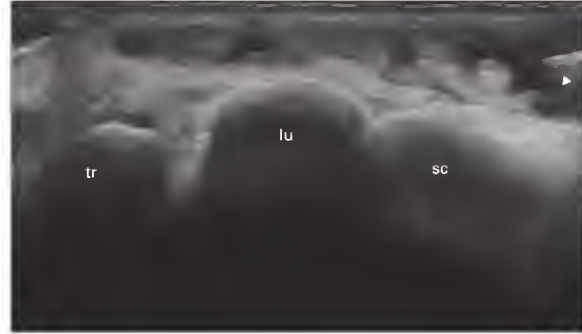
e69.10 Same patient as in [Figure e69.9](#). On the ultrasound image the needle (arrowhead) is introduced into the hypoechoic extensor tenosynovitis. lu, lunate; sc, scaphoid; tr, triquetrum.
